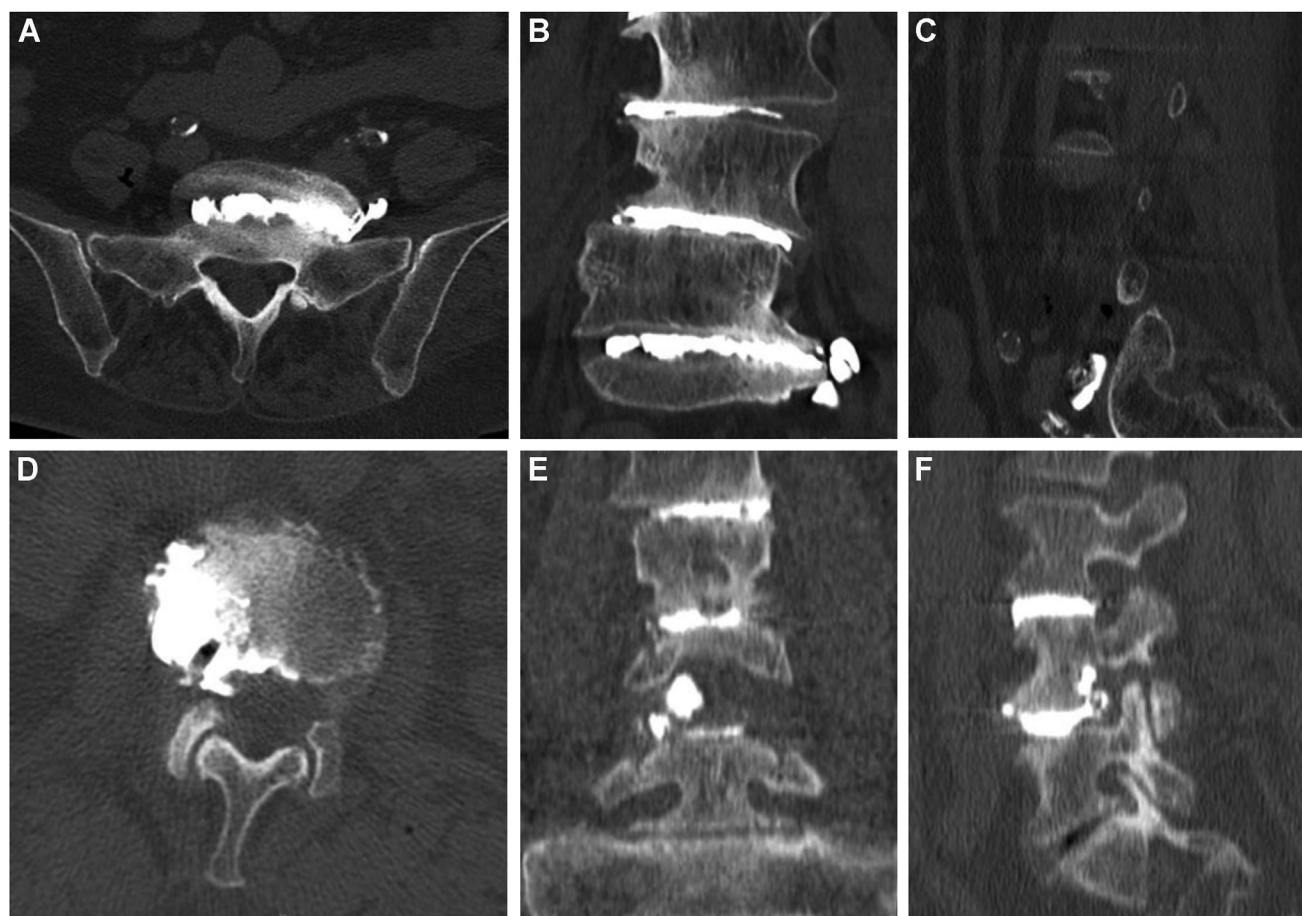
Typical types of cement leakage. (A–C) Asymptomatic, paravertebral leakage at LV/SI level on the postoperative computed tomography scan (radiologic cement leakage). (D–E) Symptomatic leakage
